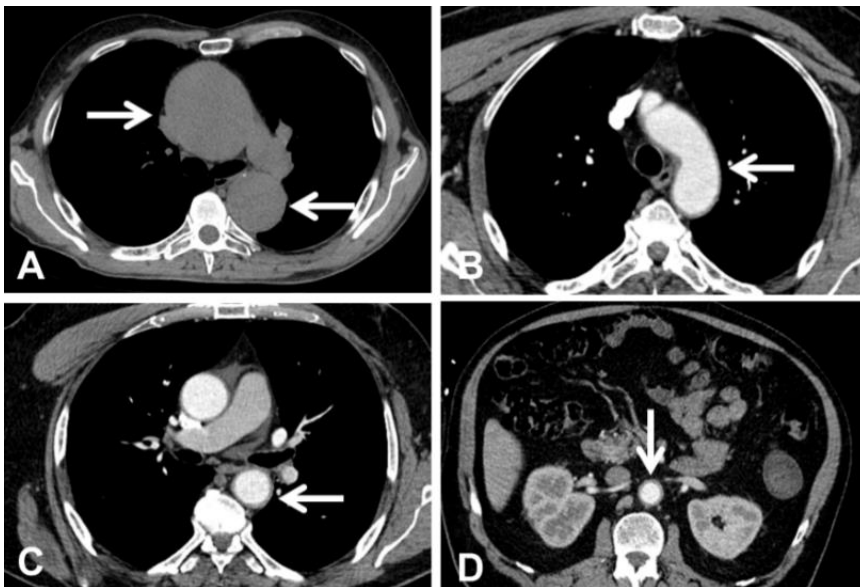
Computed tomographic (CT) findings in aortitis. The images A-C show the CT appearance of thoracic aortitis: (A) aneurysms of ascending (upper arrow) and descending aorta (lower arrow); (B, C): wall thickening of the aortic arch (B, arrow) and of the descending aorta (C, arrow). CT appearance of abdominal aortitis (D, arrow).
